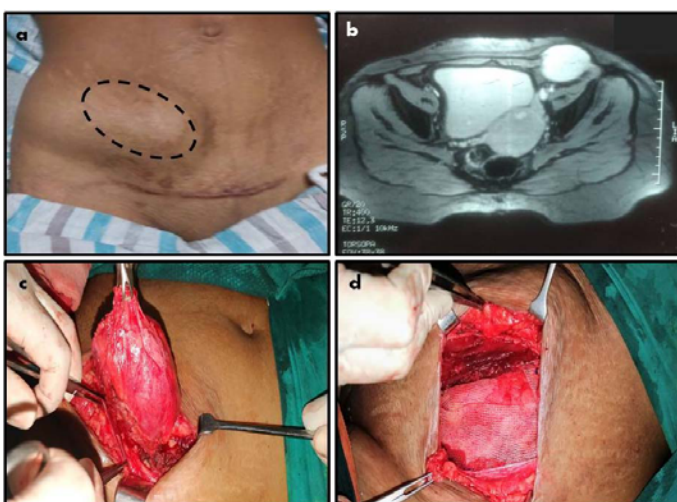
(a) Case 1 showing lesion in lower abdominal wall close to LUCS scar. (b) MRI showing lesion arising from anterior abdominal wall with no intra-abdominal extension. (c) Intra operative image showing spindle shaped tumor mass arising from anterior abdominal wall. (d) Reconstruction of post excision defect with polypropylene mesh
